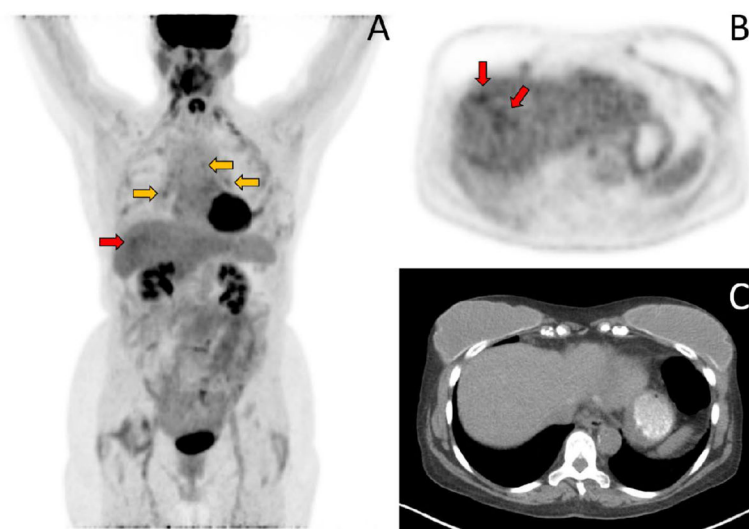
PET-CT images prior to initiating palbociclib
